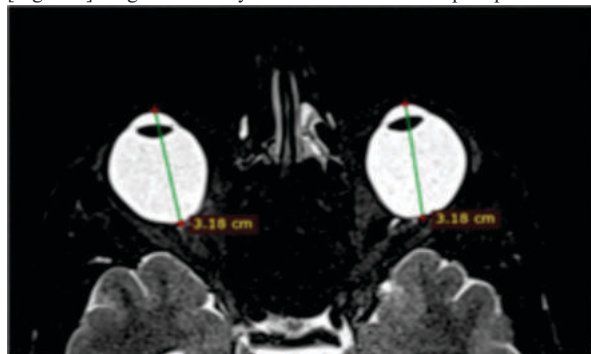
Axial T2WI of MRI Brain And Orbit Showing Increased AP Diameter Of Right And Left Eye Measuring Approx. 31.8 Mm
